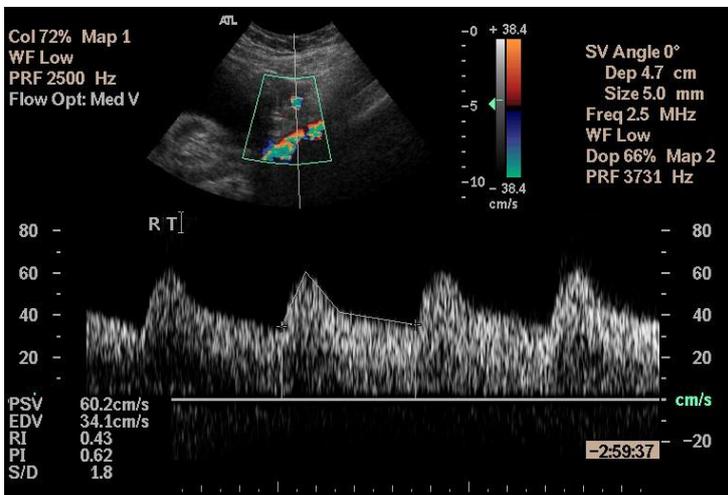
Uterine artery Doppler waveform demonstrating low resistance flow and no diastolic notch.
